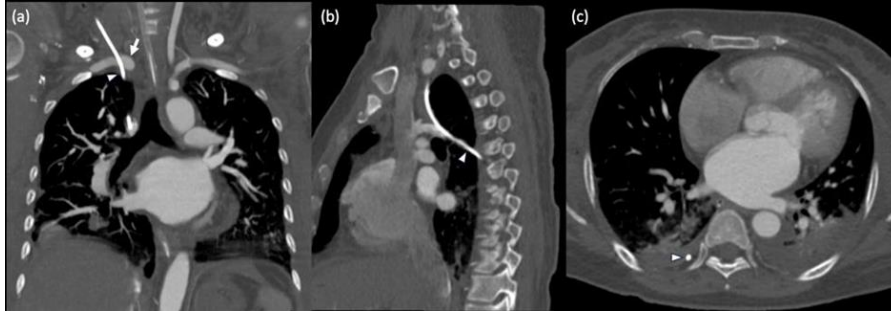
CT Angiography Thorax Showed Malposition Catheter (Arrowhead) With Its Distal Tip Within The Pleural Space At The Level Of Posterior Right Seventh Rib, Piercing The Right Subclavian Artery (Arrow).
